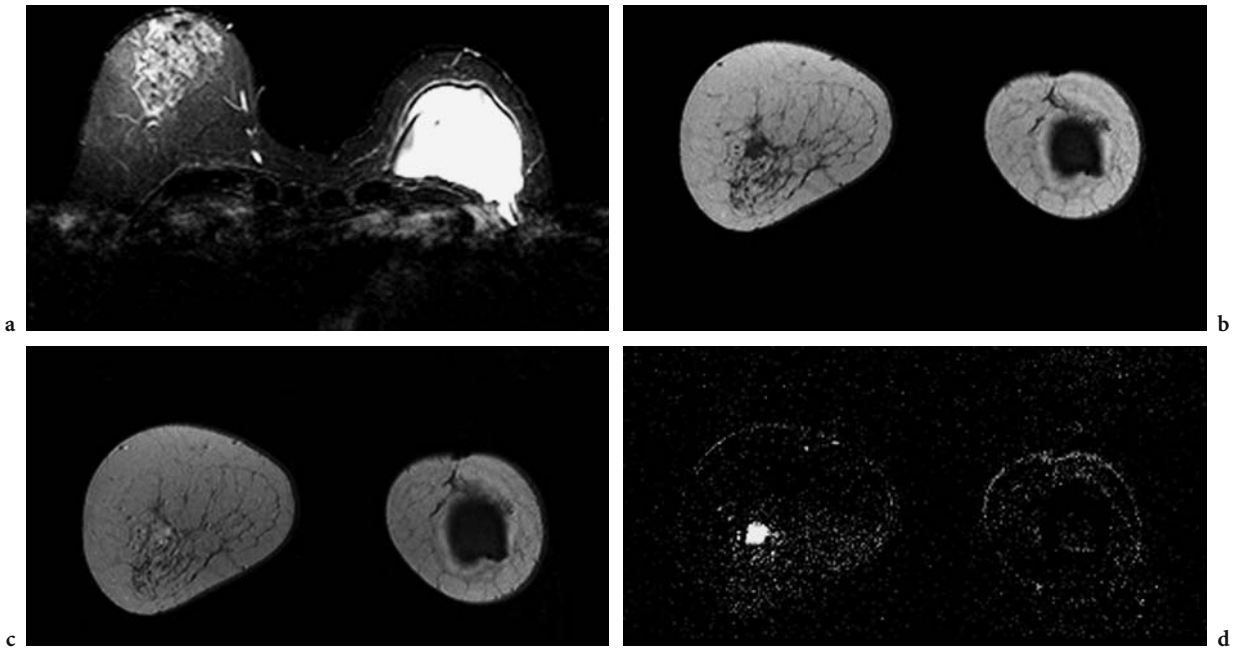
a T2 in axial plane, T1 (b) and T1 postcontrast (c) in coronal plane and subtracted (d) coronal images. Patient with previous left mastectomy for invasive ductal carcinoma and contemporary right breast reduction. MRI executed to analyze left breast implant integrity revealed cancer recurrence in the right breast
